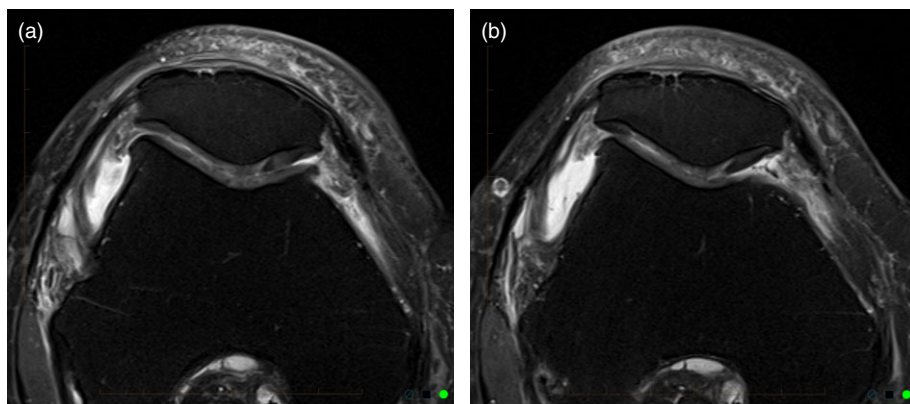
A 71-year-old male with anterior knee pain and joint swelling. (a) 3T MRI Proton density fat suppressed image in transverse plain, shows Grade 2 and 3 focal cartilage lesions of both the patella and trochlear cartilage. (b) Shows additionally Grade 3 cartilage fissure extending from the patella apex into adjacent lateral patella facet. Small joint effusion and synovitis are also noted.
